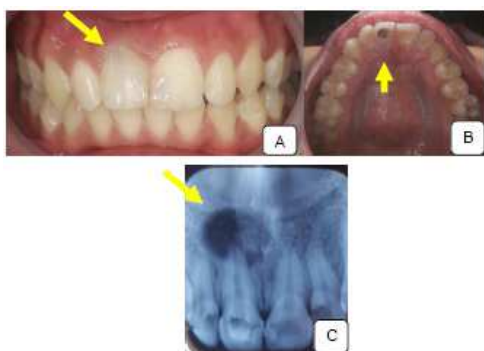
A. Clinical photograph from labial aspect showed the tooth's colour was darkened, B. Access cavity that left opened on the palatal aspect of the tooth, C. Radiograph examination show there was a radiolucent area with well defined border and the diameter was around 1 cm.
